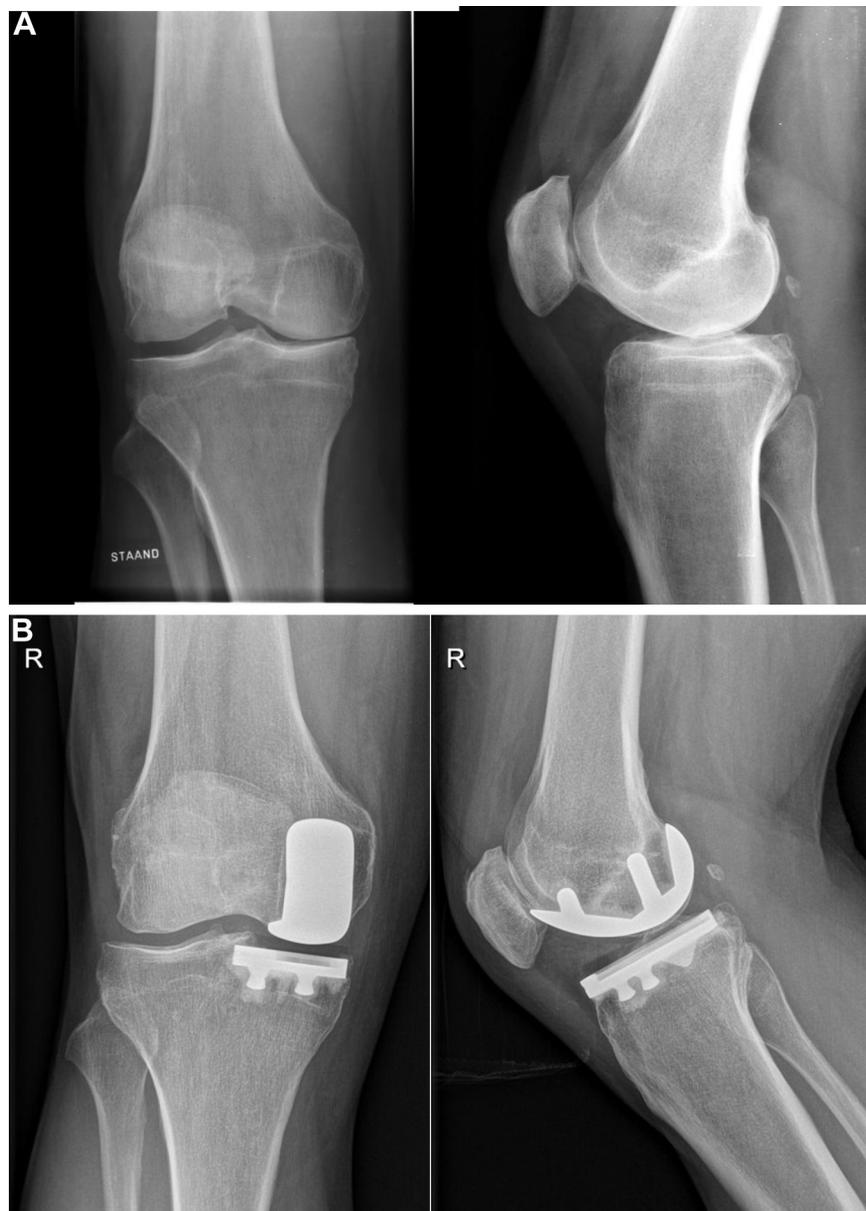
Radiographs of a male patient with a ZUK implant and a metal-back tibial component. (A) Preoperative X-rays of an active 65-year-old male patient with invalidating pain on the medial side of his right knee. The patient's BMI was 25.6 kg/m² and the limb alignment was slightly varus before surgery. His medical history did not present any relevant comorbidities. The standing X-ray showed an osteoarthritis of grade 4. (B) X-rays at 9 years after surgery. The patient reported to be pain free with an excellent recovery of the knee functionality. The X-ray has shown a well-fixed and stable implant, without any signs of progression of the lateral or patellofemoral arthritis. ZUK, Zimmer Unicompartmental Knee; BMI, body mass index.
